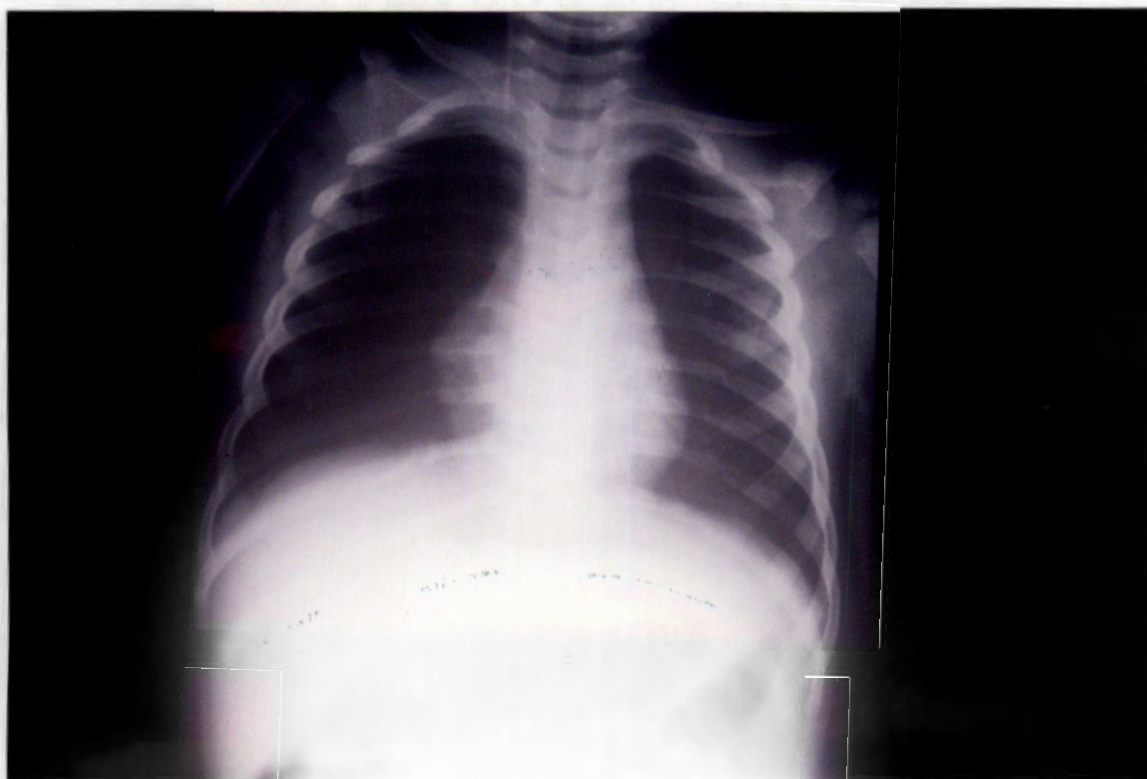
Chest X-ray 48 hours post-admission of a 2 month old boy (Case 59) with pneumoperitoneum and extensive subcutaneous emphysema caused by barotrauma.
